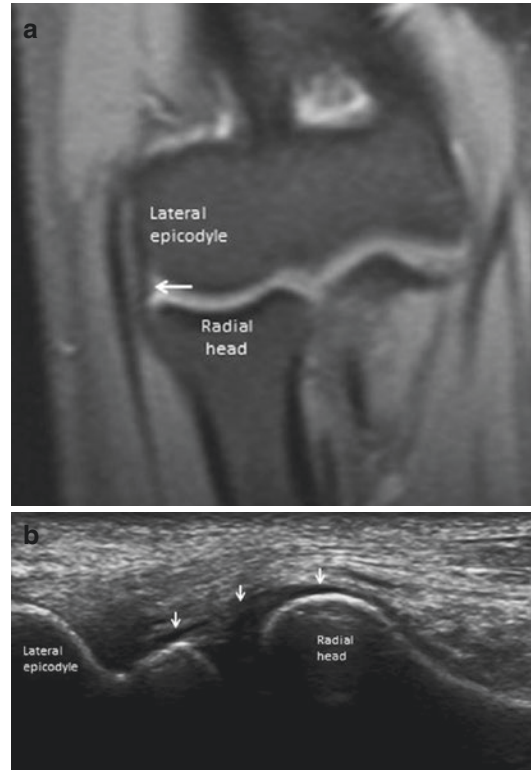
Radial collateral ligament proper. MRI image (a) of the radial collateral ligament proper (arrow) extends from the antero-inferior aspect of the lateral epicondyle to insert into the annular ligament. It is generally examined in the same position as the common extensor tendon and appears hypoechoic (arrows) (b)
